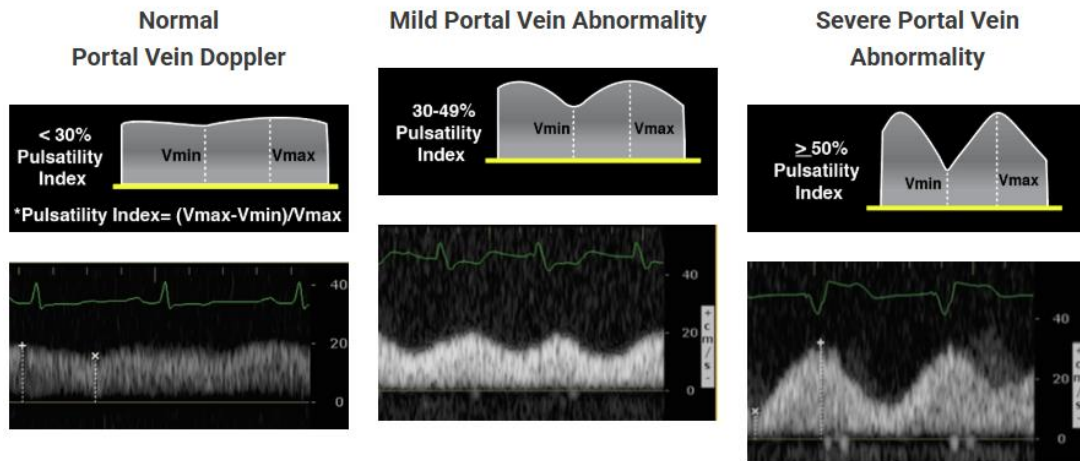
Portal Vein Ultrasound Doppler findings⁸⁹
